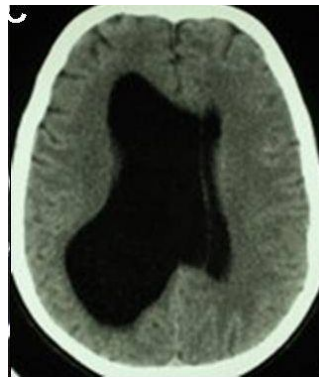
Brain CT before endoscopic surgery
